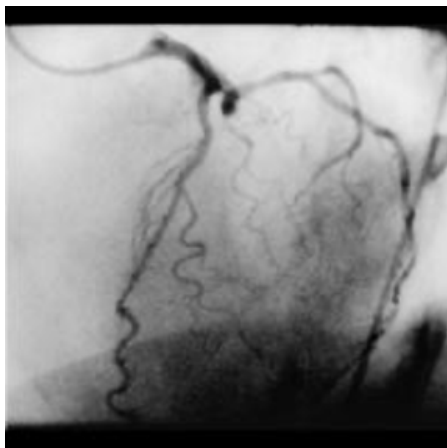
Typical X-ray angiogram of coronary arteries [5]
